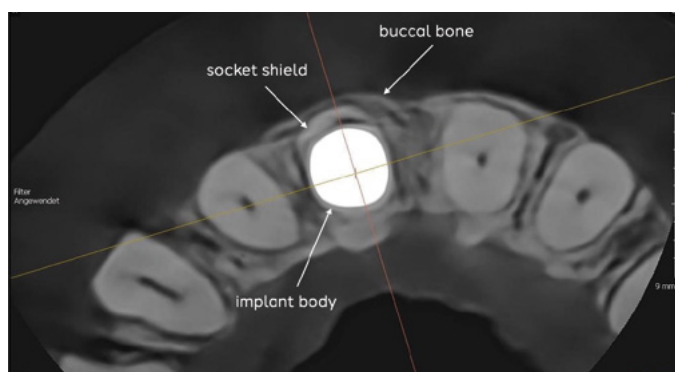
CBCT scan demonstrating successful implant integration with the socket shield
